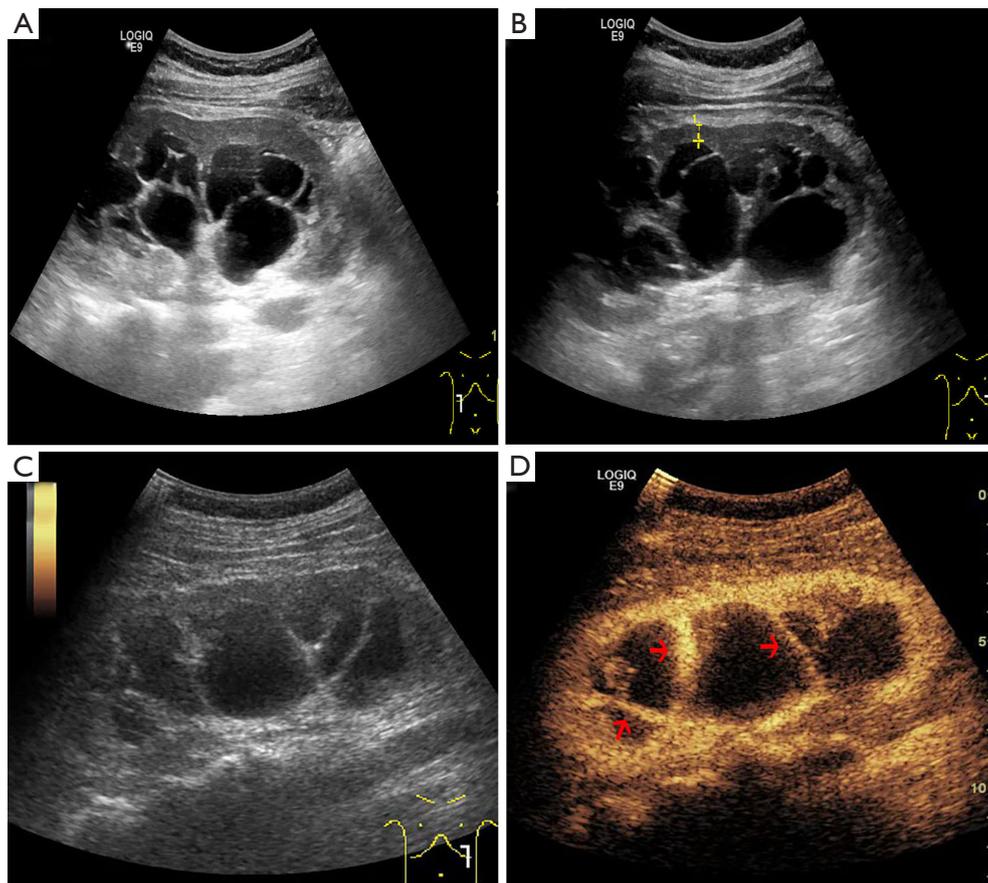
A 38-year-old female (patient A) with known renal lymphangiomatosis (case 1). (A,B) A multilocular cystic area resembling hydronephrosis was found in the renal sinus, with a fine wall and slight thickening in some areas. The renal cortex was locally thin in both kidneys. (C,D) CEUS appearance of renal lymphangioma: the capsule walls and septa are filled with contrast agent (arrows). CEUS, contrast-enhanced ultrasound.
